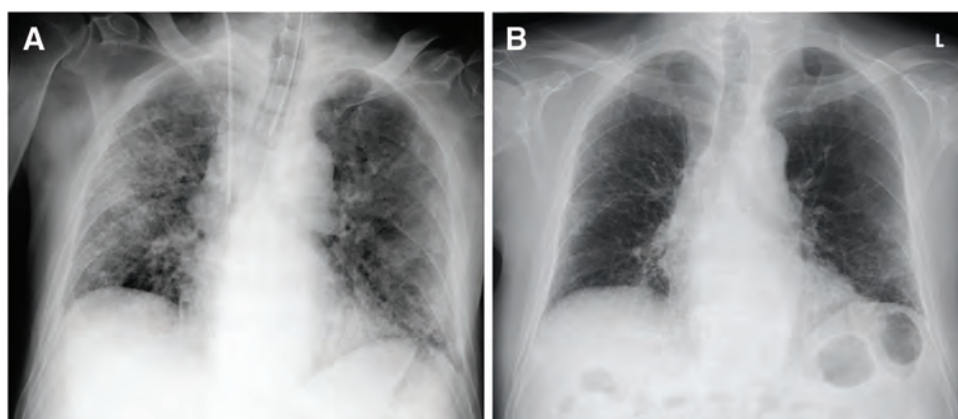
Chest radiographs obtained at ICU admission (A) and hospital discharge (B)
